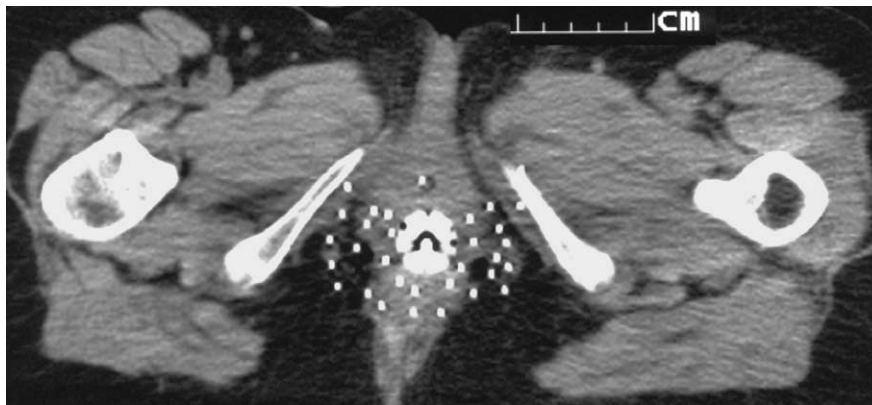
Computer tomography (CT) of a patient with cervical cancer after placing 25 cm long surgical needles of 1.17 mm diameter throughout the organ, in preparation for cancer treatment with high dose rate brachytherapy using an ^{192}Ir -source.
